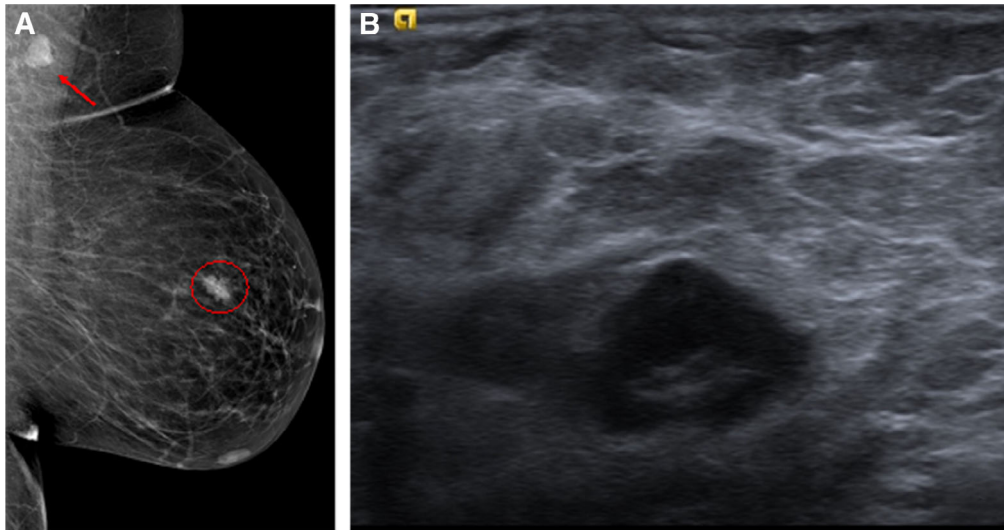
Female patient aged 40 years with an invasive ductal carcinoma in the left breast. (A): Left digital mammography, mediolateral-oblique projection, demonstrates a high-density lymph node in axilla and an irregular mass, spiculated, in the upper quadrants. (B): Ultrasonography confirmed the suspicious nature of the mass (Breast Imaging – Reporting and Data System [BI-RADS] score 5) and a single enlarged lymph node in the axilla suspicious for metastatic involvement.
